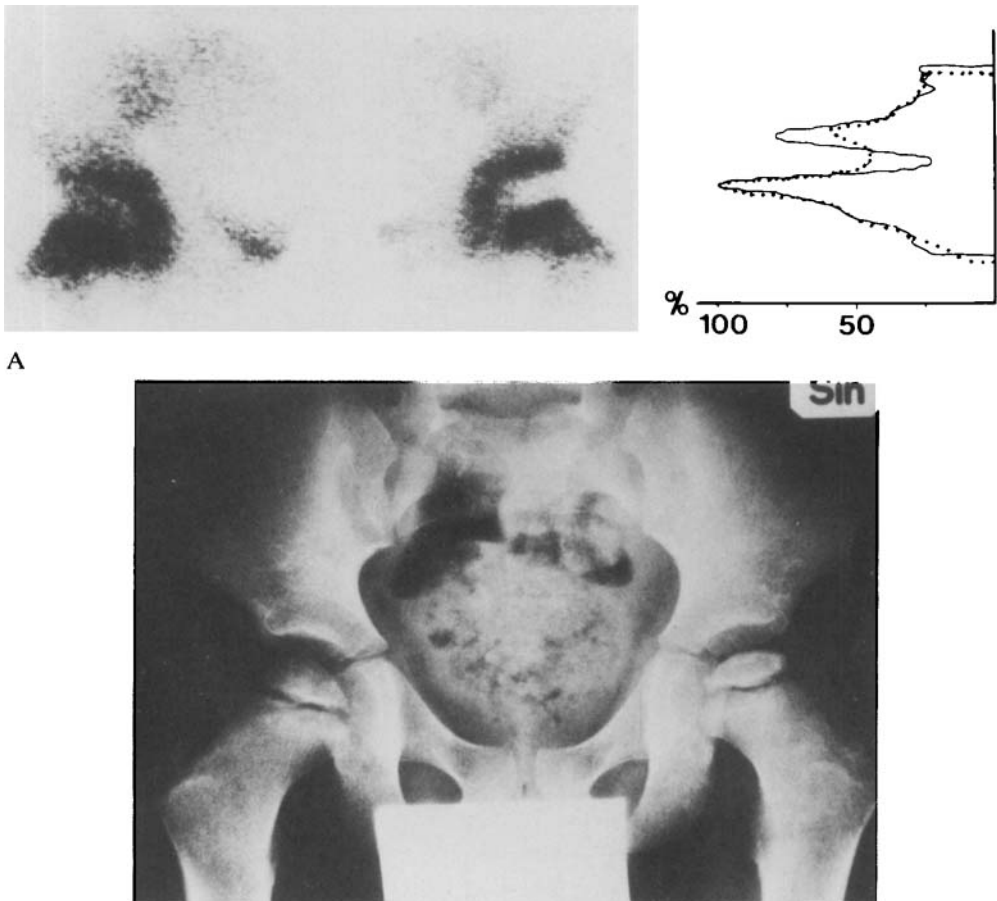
Case 3 with left hip pain and initial normal radiographs but with future Perthes disease development. Profiles of uptake superimposed as in figure 16. Drawn line = left hip, dotted line = right hip.
